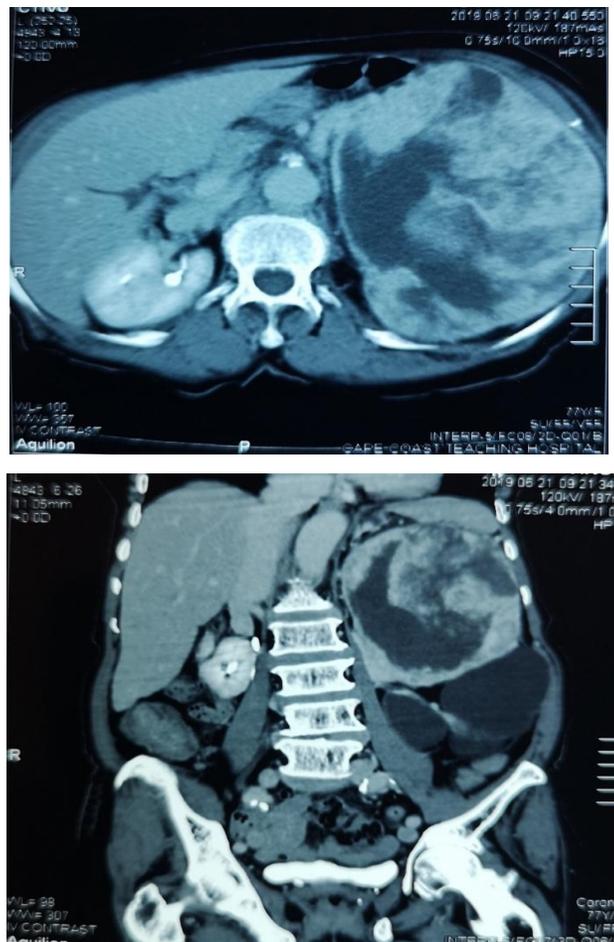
Contrast enhancing CT images of the abdomen showing a huge, well delineate, heterogeneously enhancing mass of the left kidney
